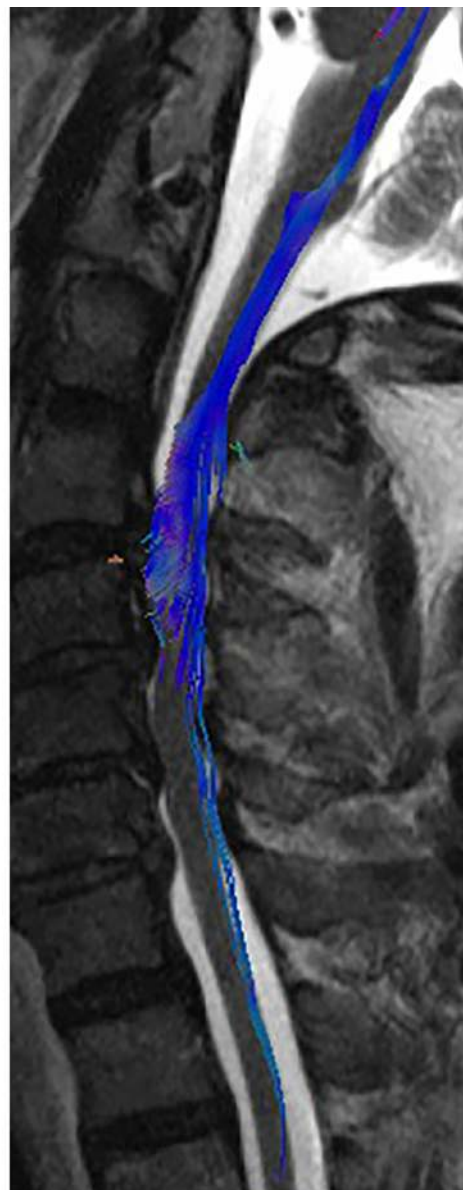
An example of a sagittal fiber tracking map that is fused onto a T2-weighted MR image by using postprocessing software. The image demonstrates significant disruption of the fiber tracts in the setting of an ASIA grade A SCI.
